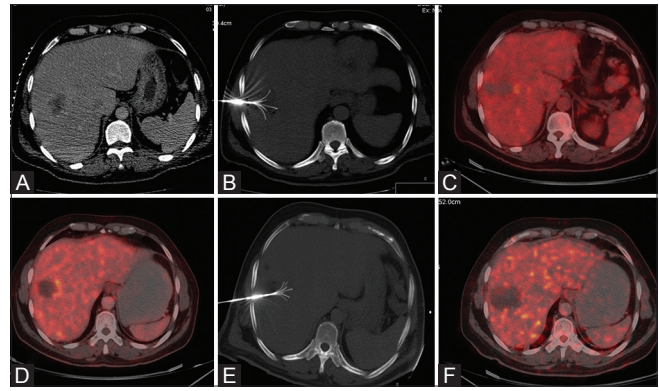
(A-F): 63 years male, operated case of Ca sigmoid colon presented with solitary segment VII FDG avid lesion (A), Radiofrequency ablation done using multitined monopolar electrode (B), Post RFA arterial phase CT (C) reveals ablation area with normal reactive zone of marginal hyperemia. Post RFA PET CT (D) reveals complete regression of FDG activity suggestive of complete ablation. 3 months and 1 year post procedure PET CT revealed complete response (E and F)
